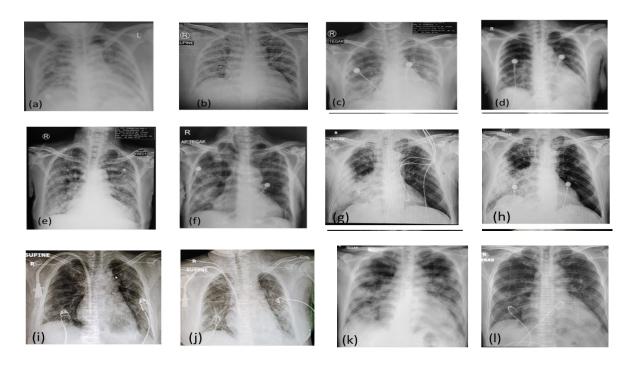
Serial chest X-ray before and after hemoperfusion. Left: before HP, Right: after second HP (a),(b) Case 1; (c),(d) Case 2; (e),(f) Case 3; (g),(h) Case 4; (i),(j) Case 5; (k),(l) Case 6
